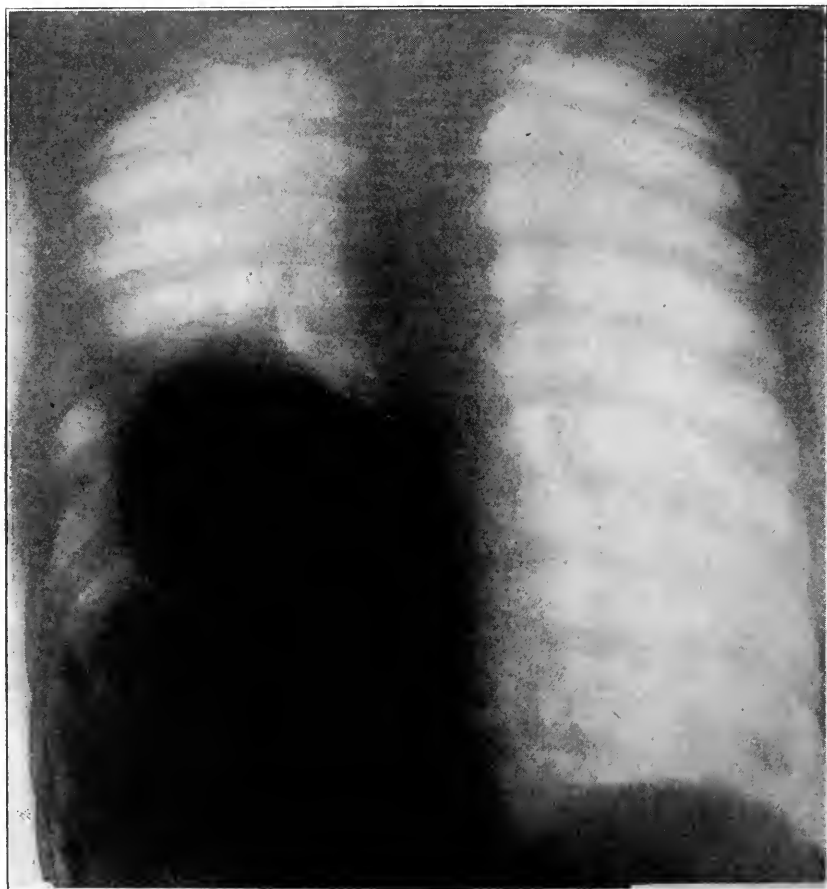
Roentgenogram of Case 2. Viewed from the back.
